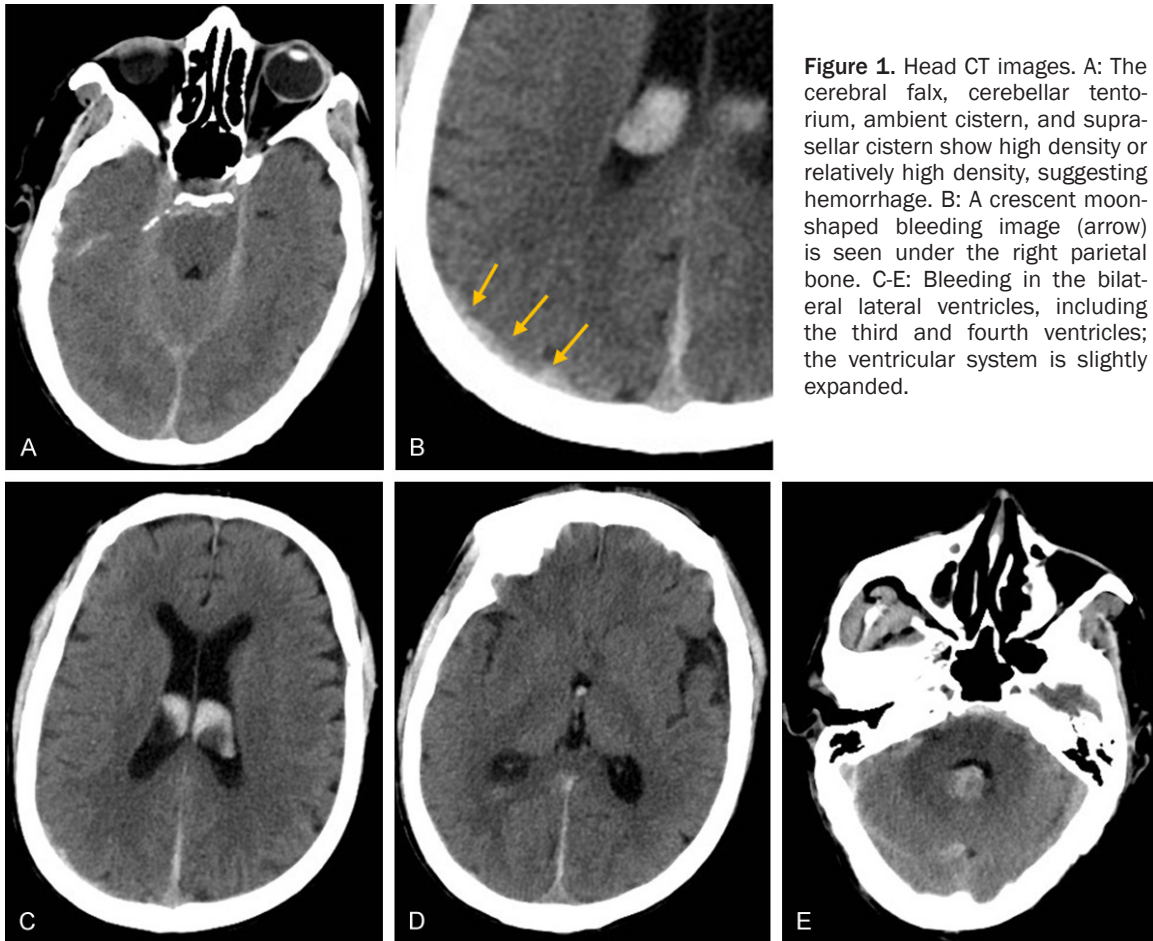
Head CT images. A: The cerebral falx, cerebellar tentorium, ambient cistern, and suprasellar cistern show high density or relatively high density, suggesting hemorrhage. B: A crescent moon-shaped bleeding image (arrow) is seen under the right parietal bone. C-E: Bleeding in the bilateral lateral ventricles, including the third and fourth ventricles; the ventricular system is slightly expanded.
